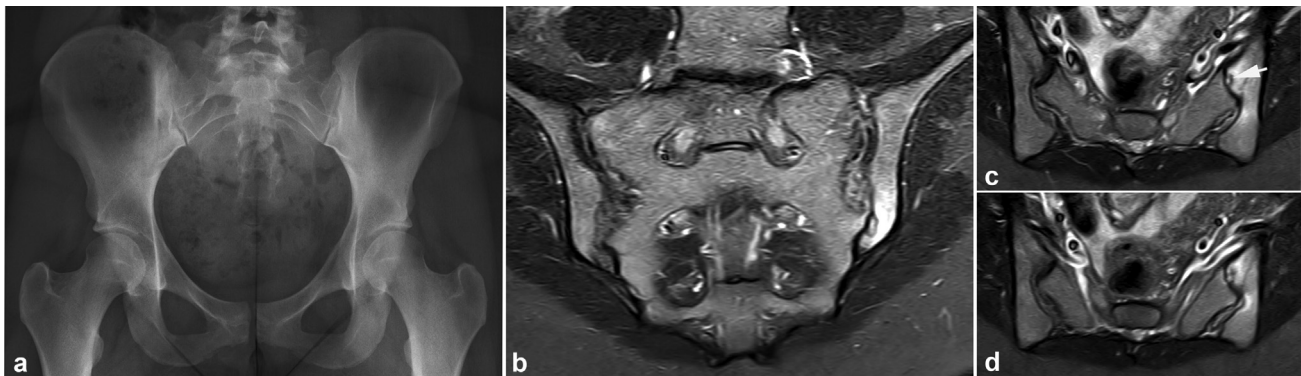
A 20-year-old woman positive for human leukocyte antigen (HLA)-B27 with non-radiographic axial spondyloarthritis who complained of buttock pain for 10 months. (a) Pelvic radiograph without signs indicating sacroiliitis except slight subchondral sclerosis in the ileum at the left sacroiliac joint (SIJ). (b-d) Supplementary magnetic resonance imaging, semi-coronal and two semi-axial short tau inversion recovery images, show subchondral bone marrow edema at the inferior part of the left SIJ with edema within an erosive cavity in the iliac bone (arrow).
